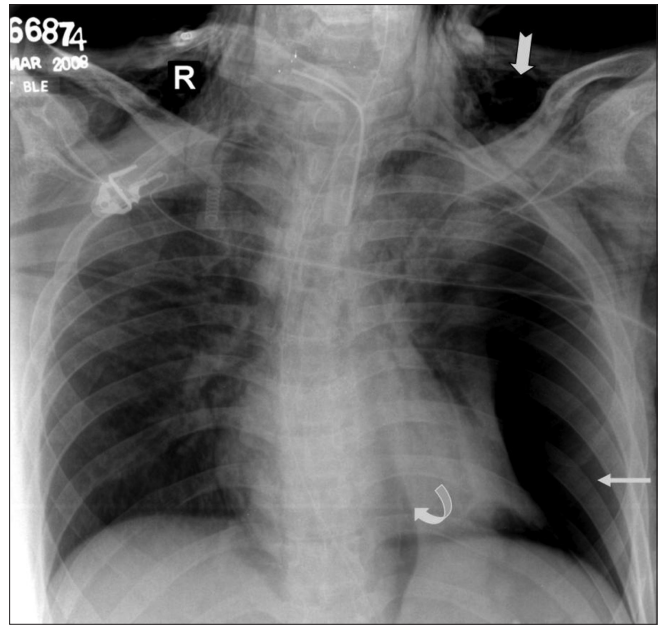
Frontal chest radiograph shows complications of tracheostomy: pneumothorax (straight arrow), pneumomediastinum (curved arrow), and surgical emphysema (notched arrow)
